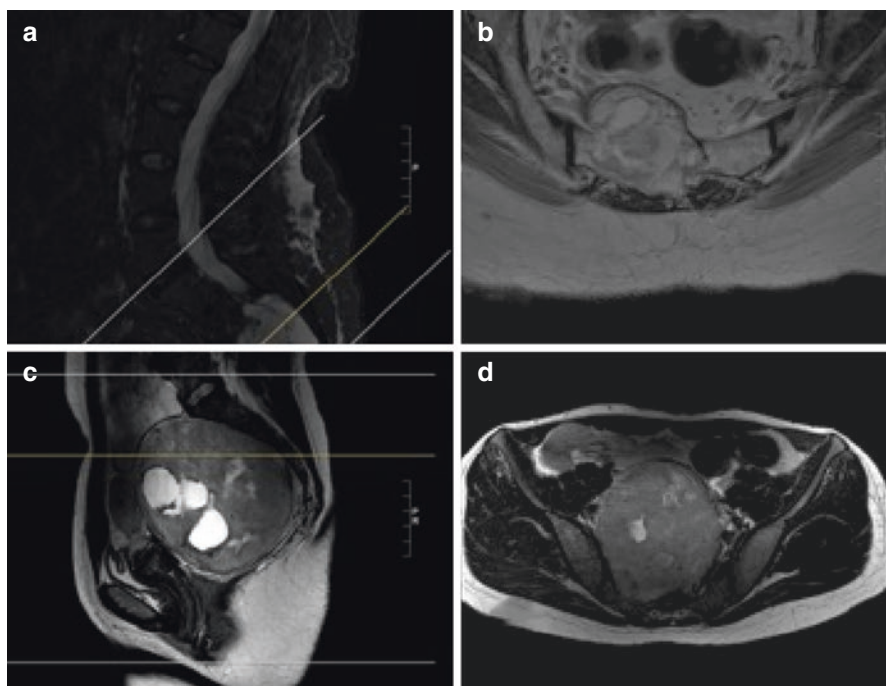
MRI sequences of 2 patients with large sacral tumors. Sagittal (a) and axial (b) images of a large right-sided sacral tumor from the first patient. Sagittal (c) and axial (d) images of a giant sacral schwannoma
